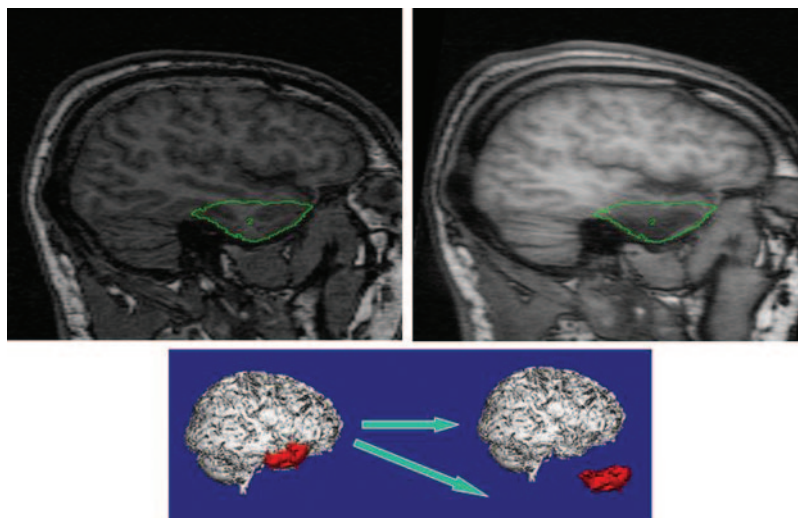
Method for calculation of the volume of temporal lobe resected. The resected temporal lobe is traced on the preoperative MRI scan using the co-registered postoperative MRI as a template for the posterior resection margins.
